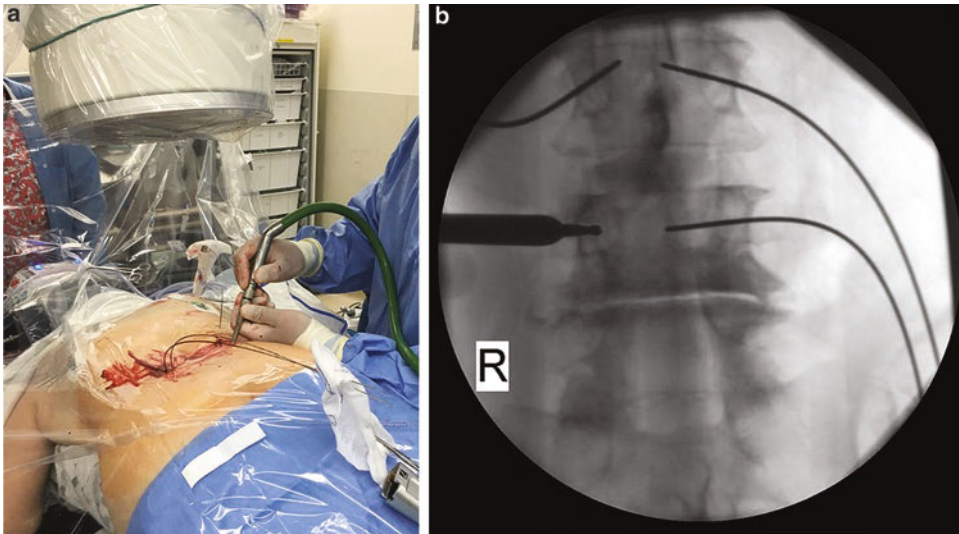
(a) The drill is carefully controlled under X-ray monitoring and used to advance into sclerotic bone. (b) The trajectory of the drill is identical to that of a usual Jamshidi needle under fluoroscopic image
